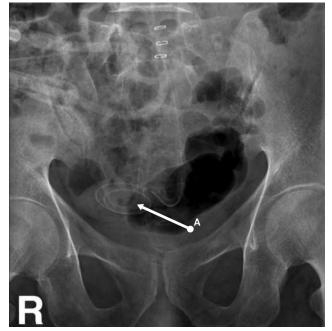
The frontal pelvic radiograph showing that the tip of peritoneal dialysis catheter is within the lower pelvic cavity. Few surgical clips are seen projecting over the lower abdomen.
